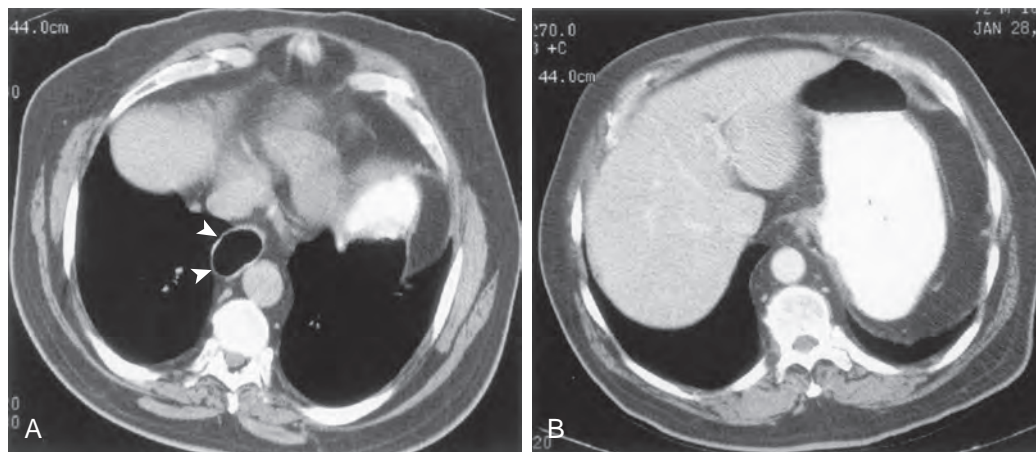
Primary achalasia on CT. A. CT scan shows a dilated esophagus (arrowheads) without esophageal wall thickening or mediastinal adenopathy. B. Another scan more caudally shows no evidence of a soft tissue mass at the gastroesophageal junction. (Note barium in the gastric fundus.) This patient had long-standing primary achalasia.
